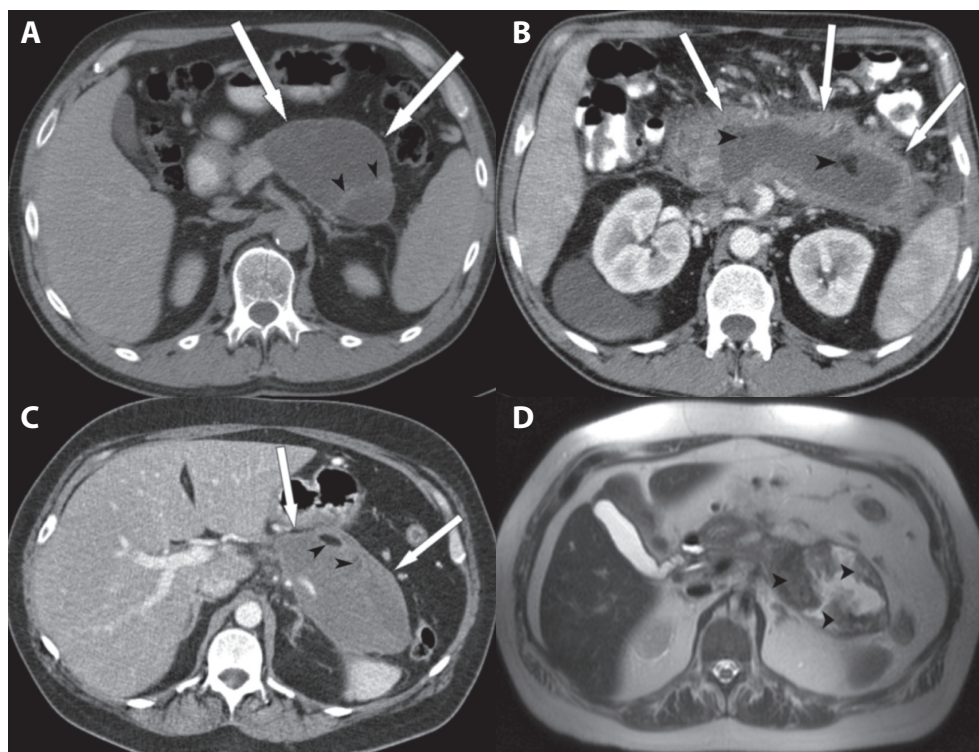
(A-C) Three different patients with walled-off necrosis (WON) after an acute attack of necrotising pancreatitis. In all three patients, a heterogeneous, fully encapsulated collection is noted in the pancreatic and peripancreatic area. (A) Non-liquid components of high attenuation (black arrowheads) in the collection are noted. The collection has a thin, well defined, and enhancing wall (thick white arrows). (B, C) A largely liquefied collection in the bed of the pancreas is observed with non-liquid components representing areas of trapped fat (black arrowheads). (D) represents the corresponding T2-weighted MRI to (C), showing the true heterogeneity of the collection. Black arrowheads denote areas of necrotic debris surrounded by fluid (white on T2-weighted image).
